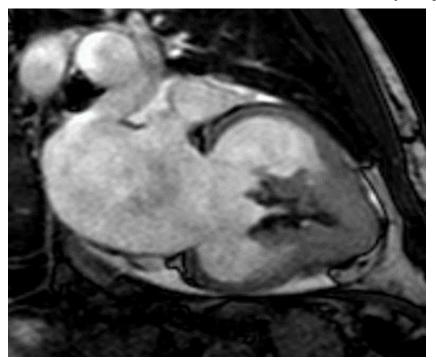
Cardiac MRI showing obliteration of the entire left ventricular apex.
